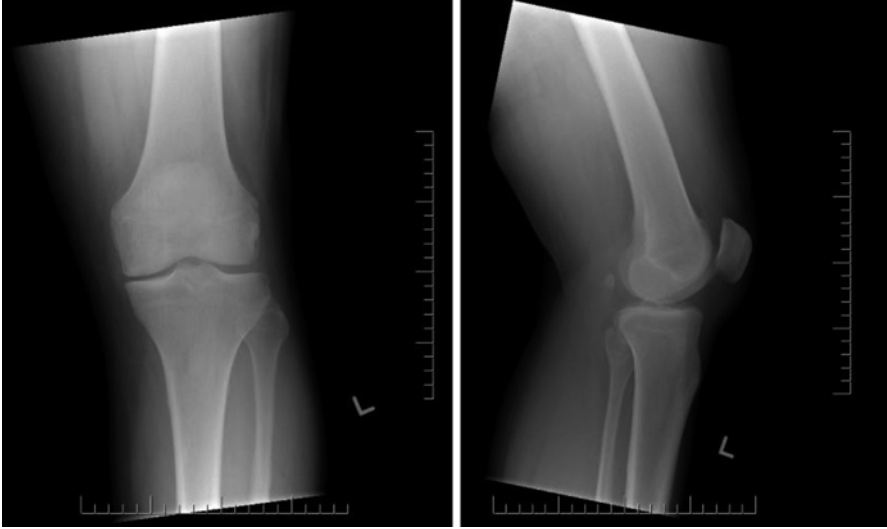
AP and lateral radiograph of the left knee demonstrating decreased medial joint space compared to the lateral compartment
